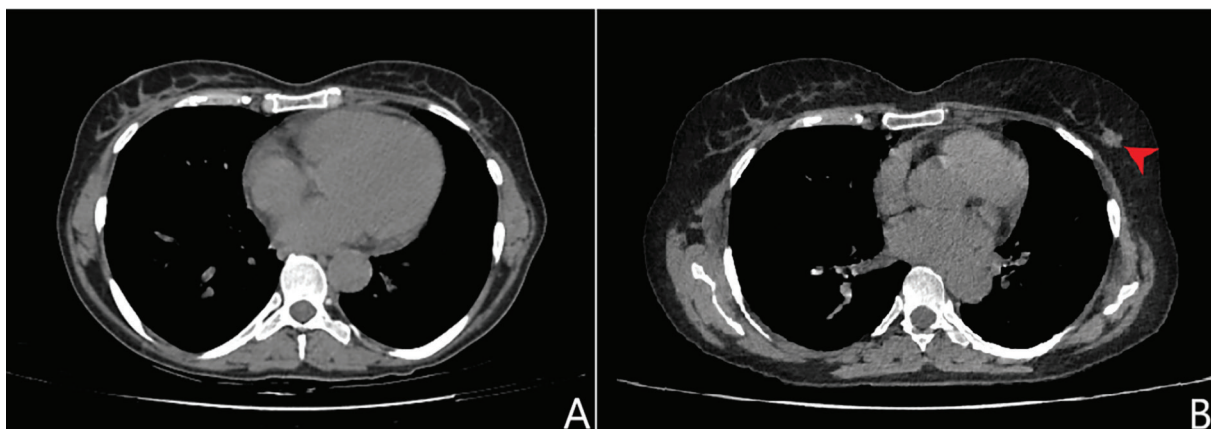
(A) Preoperative chest computed tomography (CT) scan showing no breast lesion. (B) Five months after rectal cancer surgery, chest CT scan showed a soft tissue density mass (10*13 mm) in the left breast (red arrow).
